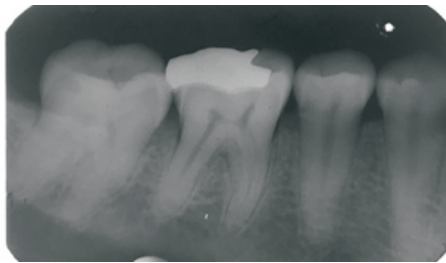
7- Radiograph after cementation of prosthesis
